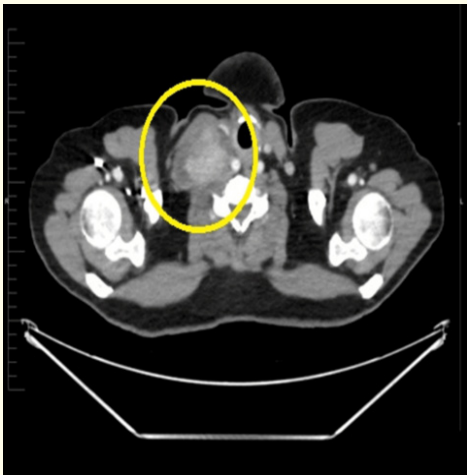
An Axial Computed Tomography (CT) showed lateral right neck mass marked with a yellow circle.
